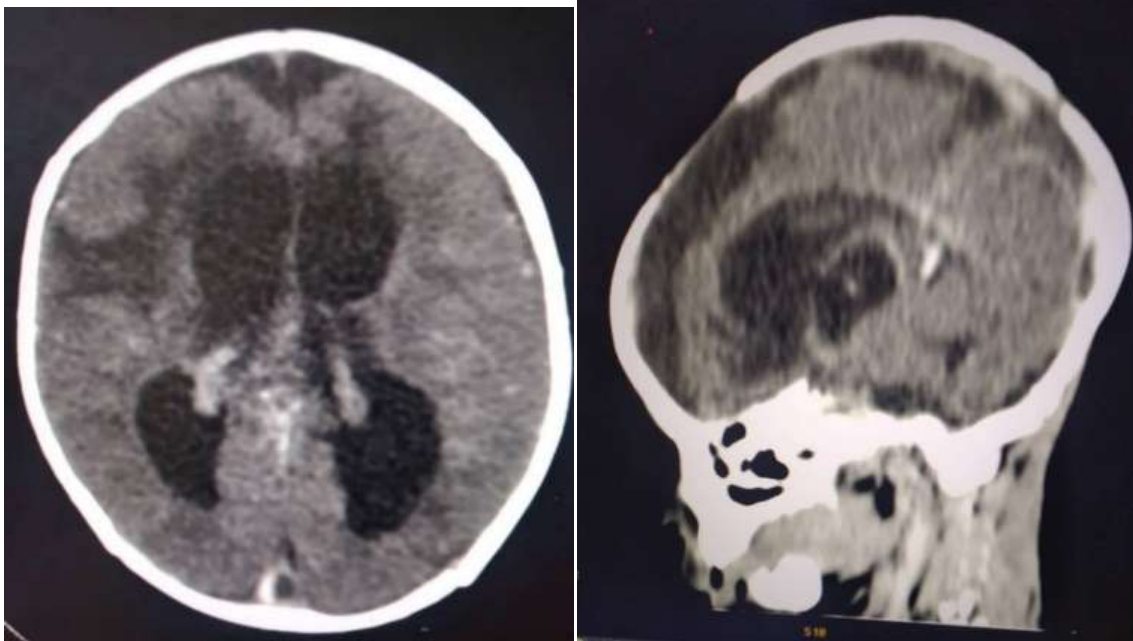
Axial brain CT section after injection of contrast product.
